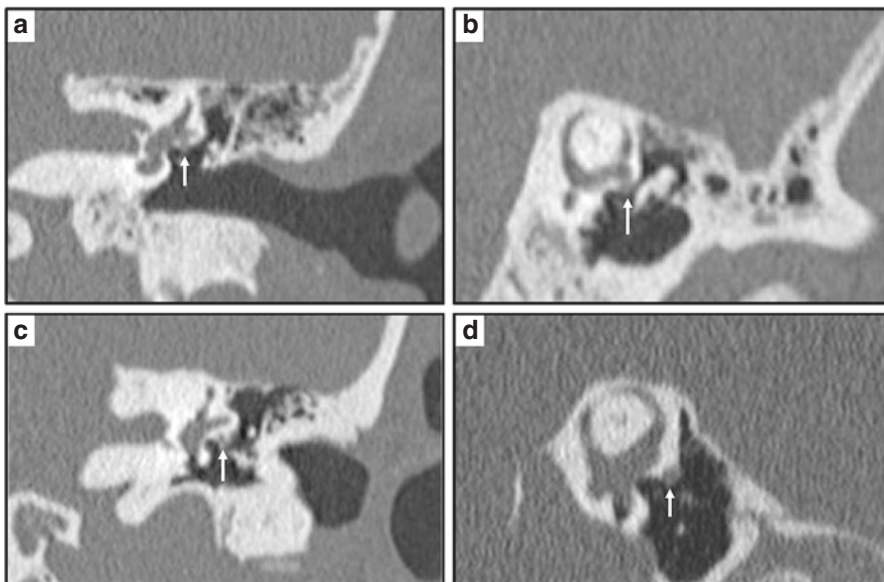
CT scan demonstrating (a) HSC-FND on coronal imaging, (b) HSC-FND on Poschl imaging, (c) normal HSC and facial nerve anatomy on coronal imaging, and (d) normal HSC and facial canal on Poschl imaging
